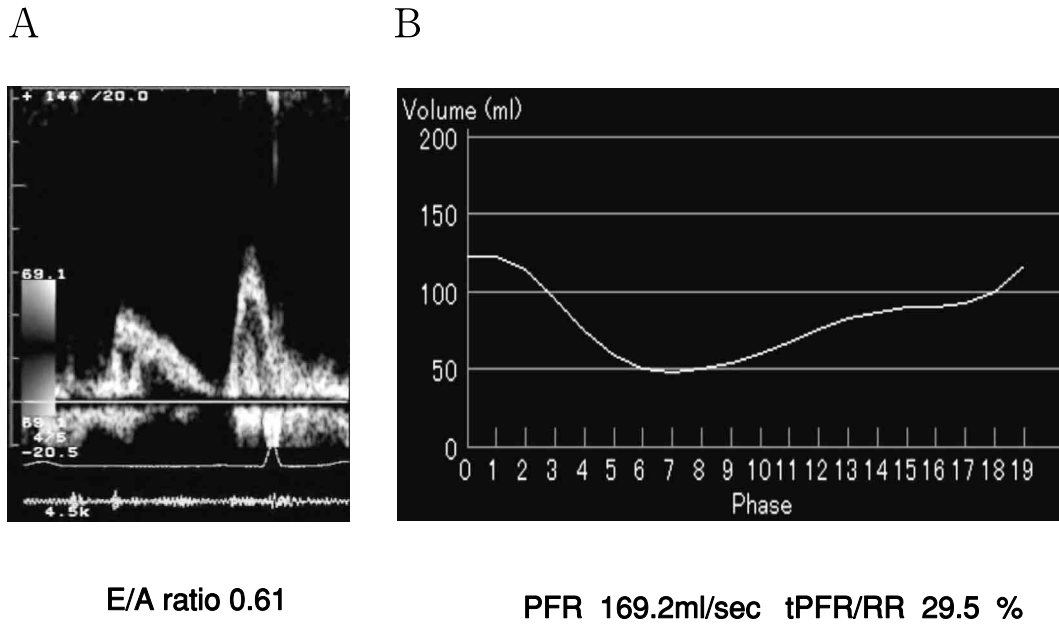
Doppler E/A ratio determined by UCG (A) and the left ventricular time-volume curve determined by MDCT (B). E/A ratio, the ratio of the peak E wave (early diastolic inflow wave) velocity to the peak A wave (atrial systolic wave) velocity; UCG, ultrasound echocardiography; MDCT, multidetector-row computed tomography.
